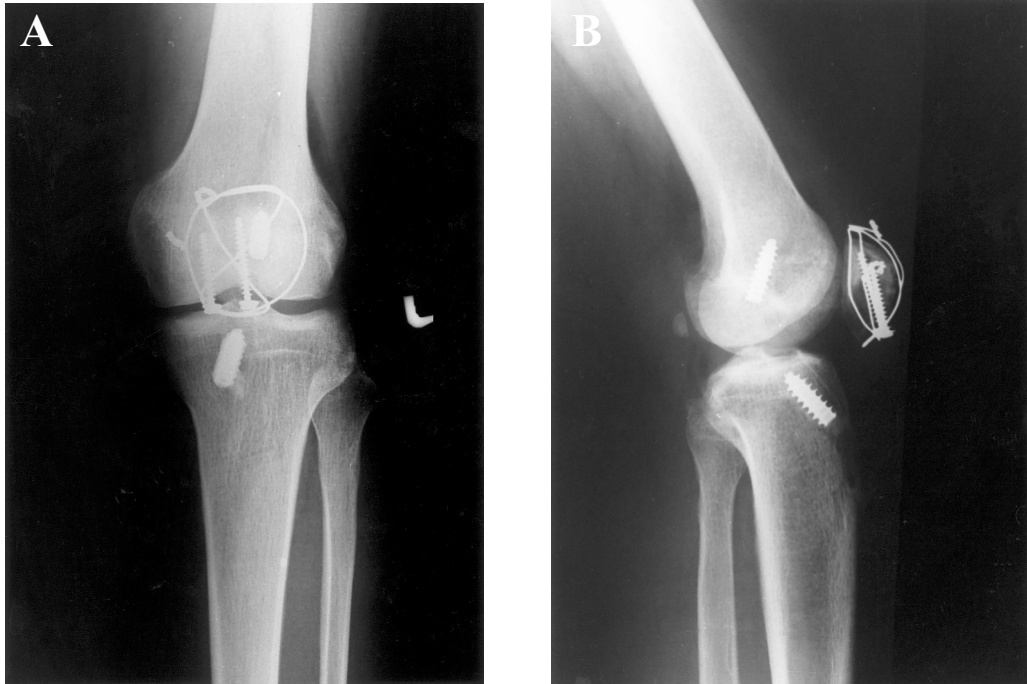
(A) Anteroposterior and (B) lateral radiographs of the knee taken 4 months postoperatively showing complete healing of the fracture.
